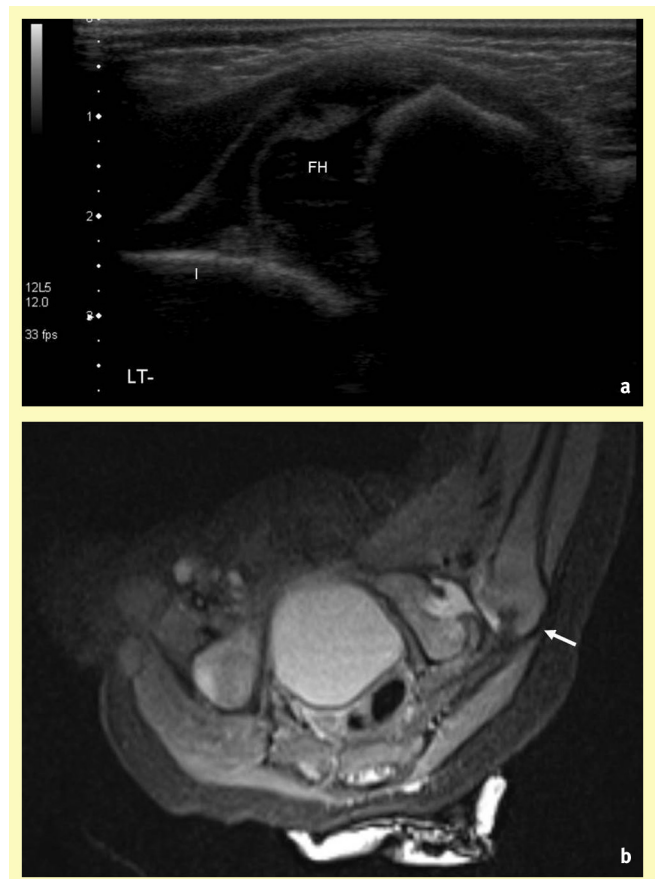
(a) Ultrasound shows dislocated left hip in a 4 day old infant. Note the speckled appearance of the head (FH), which lies away from the ilium (I) and dysplastic acetabulum. (b) Axial T2w fat suppressed MRI of the same patient shows the left femoral head is dislocated posteriorly (white arrow).
